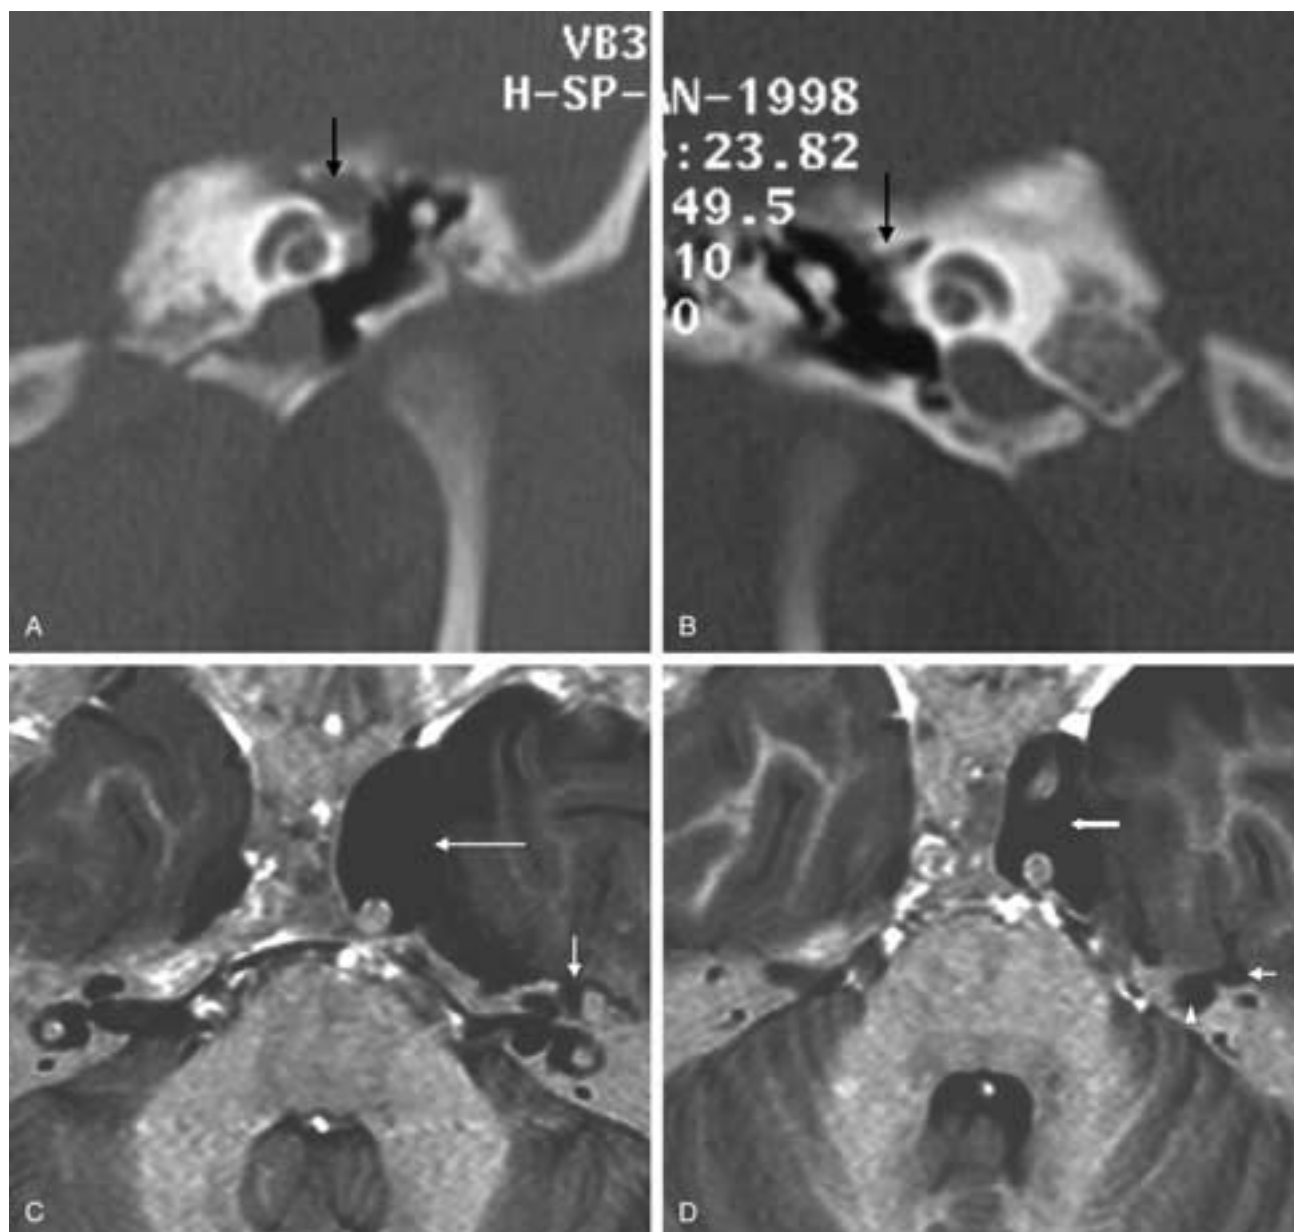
Possible perilabyrinthine fistula: lateral extension of the subarachnoid space surrounding the facial nerve within the IAC extending into the labyrinthine segment and geniculate ganglion region (GG) of the facial nerve canal, with a coexisting middle cranial fossa meningocele. A, Coronal CT image showing enlarged left GG (*black arrow*). B, Coronal CT image of the normal right side and normal right GG (*black arrow*). C, Axial MR image showing an enlarged left GG (*vertical white arrow*). Note also the large congenital meningocele of the central skull base/middle cranial fossa (*horizontal white arrow*). D, Axial MR image showing a prominent left GG (*small white arrow*) and a widened IAC (*white arrowhead*). Again, note the meningocele (*large white arrow*).
